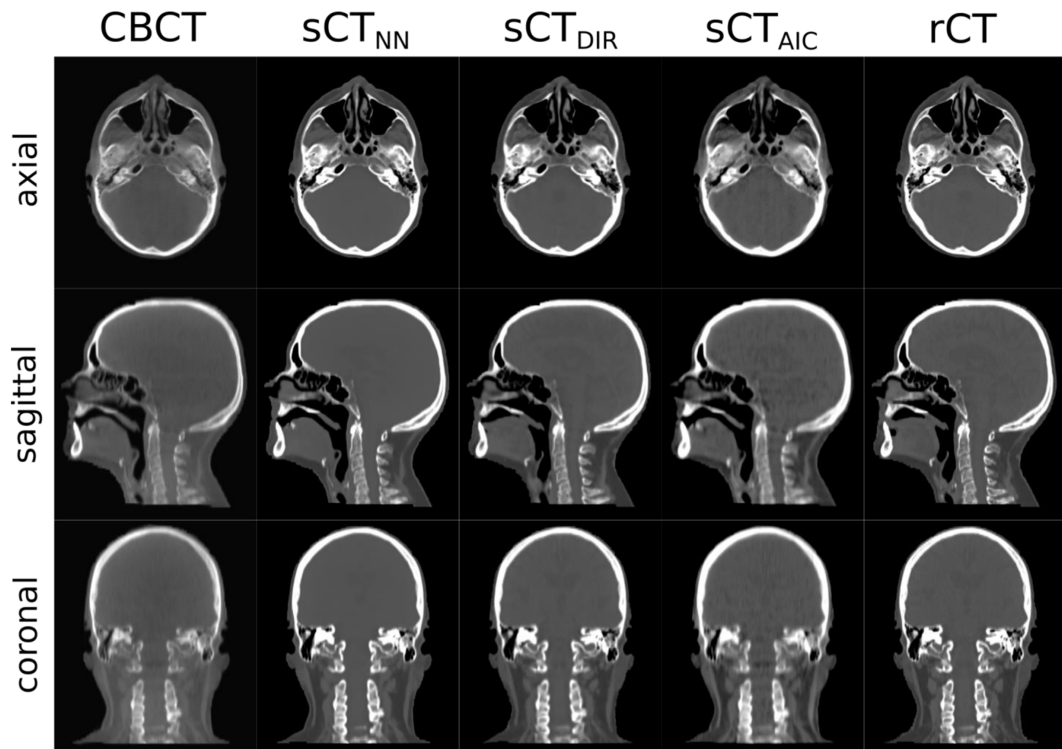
Comparison of CBCT, the various sCTs (sCT_{NN} , sCT_{DIR} and sCT_{AIC}) and the reference rCT images in axial, sagittal and coronal views for patient 15. The same HU-windowing settings [WL = 250, WW = 1250] were applied to all images except for the CBCT, where a window of [1900, -100] was used. The MAE values for this patient are: sCT_{NN} = 35.8 HU, sCT_{DIR} = 43.4 HU and sCT_{AIC} = 78.2 HU. Gamma pass ratios (2%/2 mm) are: sCT_{NN} = 99.2%, sCT_{DIR} = 99.5% and sCT_{AIC} = 98.4%.
